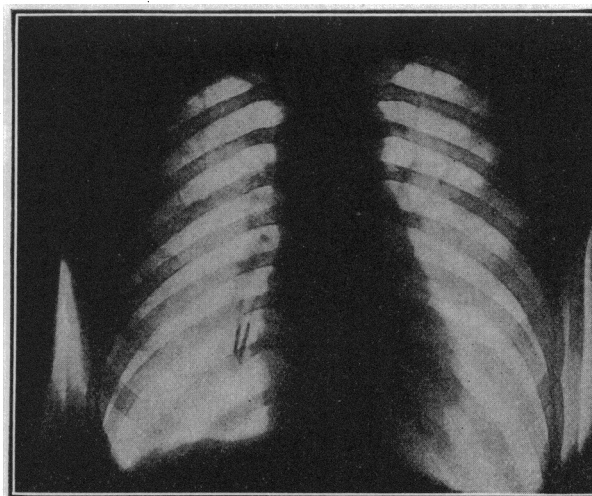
Anteroposterior view of chest showing staple in a posterior branch of the inferior-lobe bronchus. (From roentgenogram by Dr. George W. Grier.)
